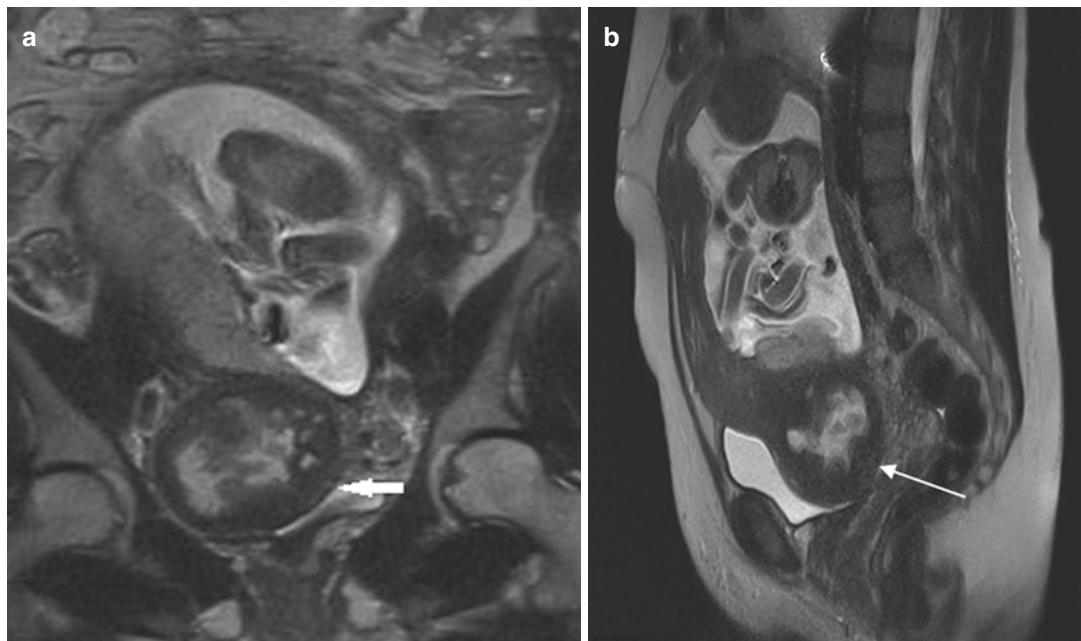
Degenerated leiomyoma in a 28-year-old woman at gestational week 25 with acute pelvic pain. Coronal (a) and sagittal (b) T2-weighted images show a well-circumscribed uterine mass with variable signal
